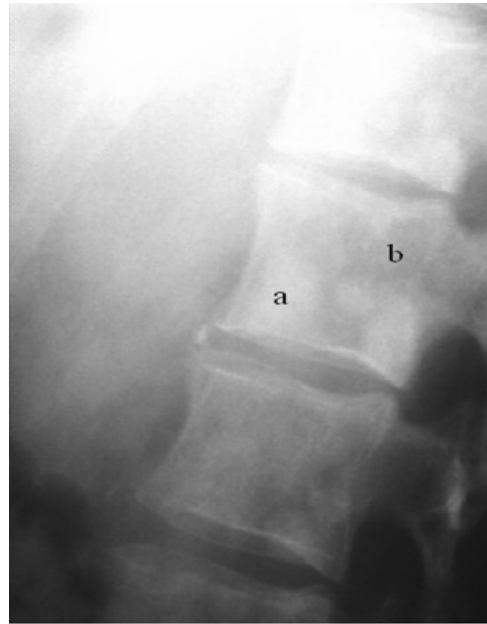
Plain radiography of the lumbar spine (lateral view) demonstrating mixed osteoblastic (a) and osteolytic (b) metastases.
